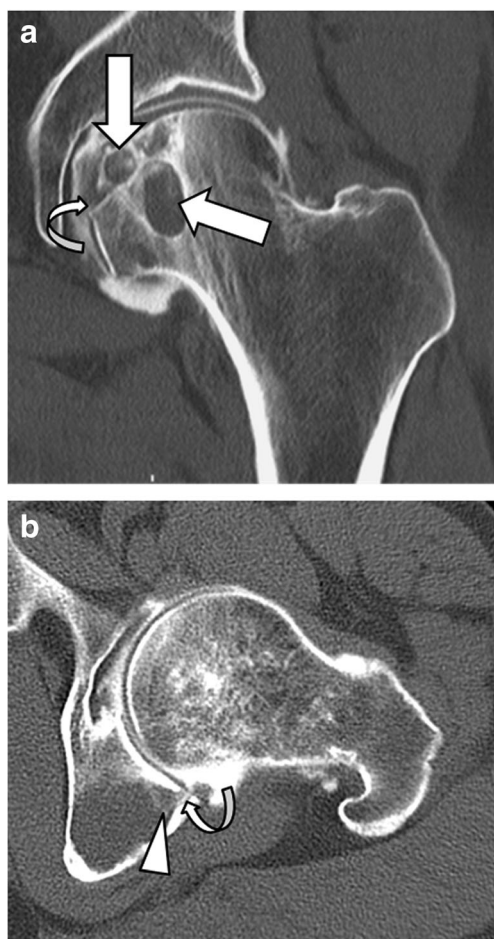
Computed tomographic arthrography, reformatted a coronal and b transverse images show partial opacification of the lytic lesions of the femoral head (arrows in a) and the ilio-ischiatic tuberosity (arrowhead in b) by contrast material (compared with Fig. 2), and demonstrate the interruption of the subchondral bone plate, showing the articular origin of the cysts (curved arrows)
